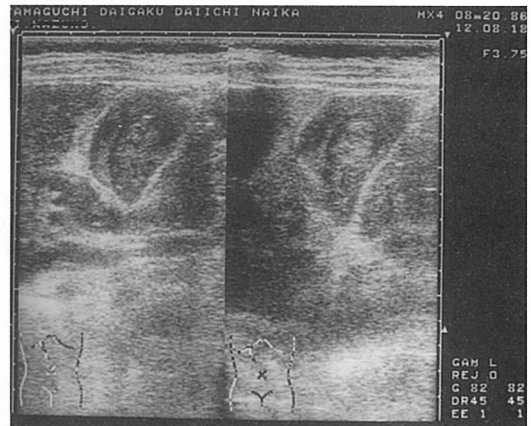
Ultrasonography on admission. The gall bladder was filled with high echoic materials.
